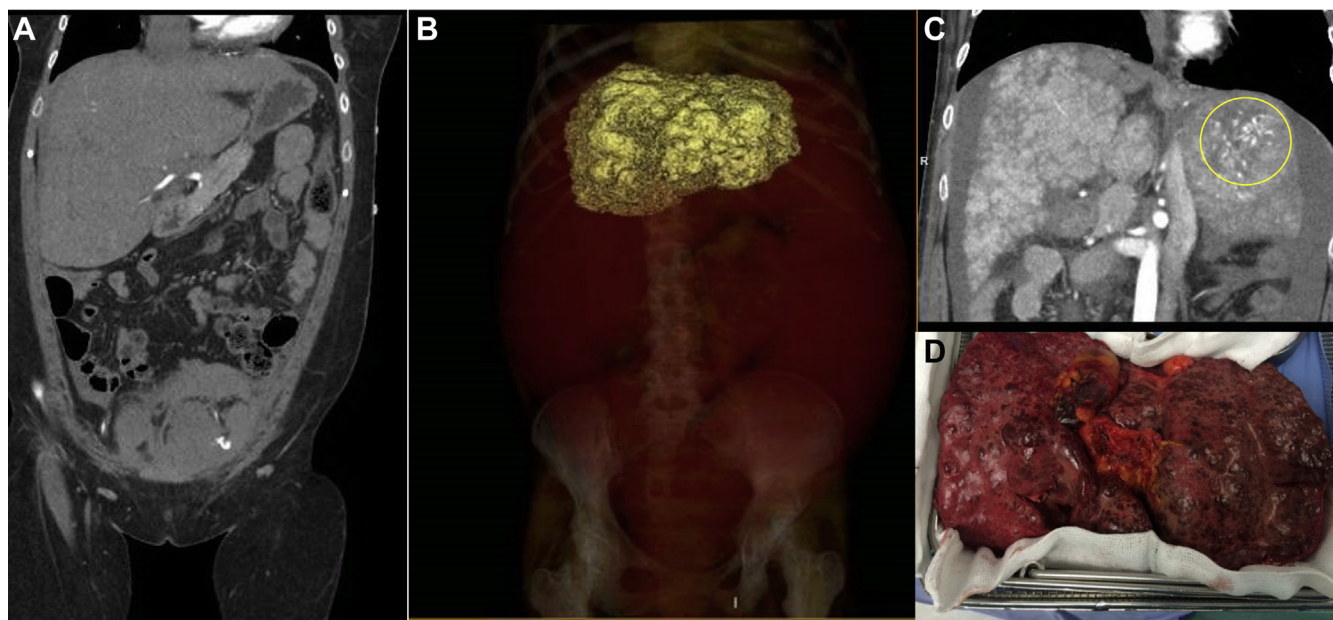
Examples of the Fontan-associated liver disease in patients referred to our heart failure (HF) in adult congenital heart disease clinics for consideration of advanced therapies. Some of the liver problems we have encountered in adults with failing Fontan circulations referred for consideration of advanced heart failure therapies. (A) Computed tomography (CT) showing hepatomegaly in patient referred for consideration of heart transplant. (B) CT showing small, shrunken, nodular liver, and massive ascites (coloured red) in right atrium to pulmonary artery Fontan patient originally referred for atrial arrhythmia ablation (unrecognized severe Fontan failure). (C) CT showing recurrent hepatocellular carcinoma (yellow circle) post ablation in RA-PA Fontan patient. (D) Explanted cirrhotic, nodular shrunken liver in a patient undergoing combined heart-liver transplant. (D) Modified from Duong et al.¹⁰¹ under license by Creative Commons (CC BY-NC-ND 4.0).
